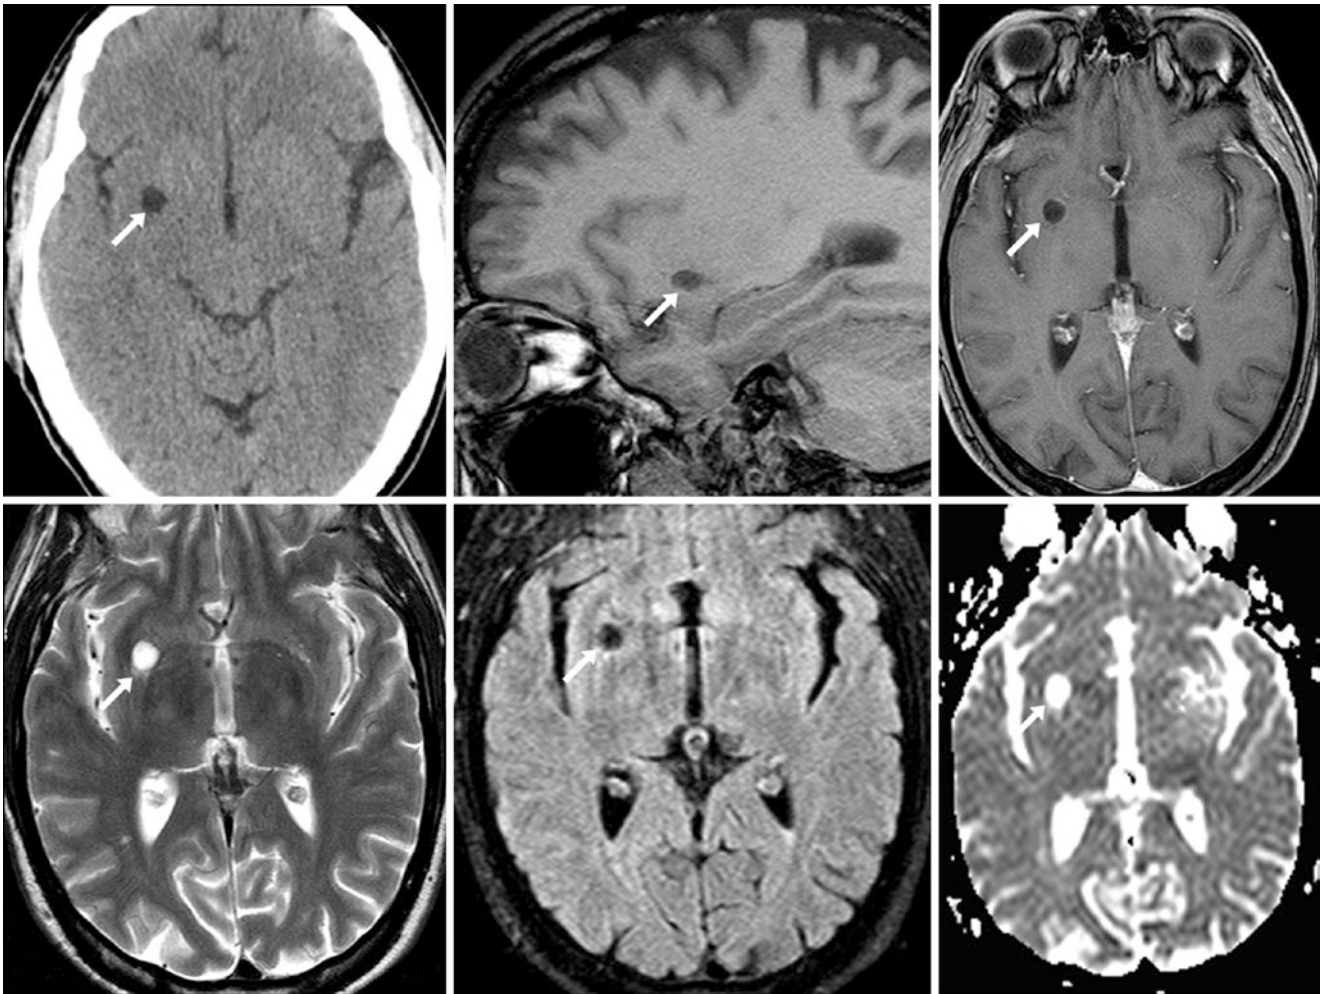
A 52 year old had a dilated PVS (arrows) within the inferior right putamen on a NECT (top left), sagittal T1WI MRI (top middle), postcontrast axial T1WI MRI (top right), axial T2WI (bottom left), FLAIR (bottom middle), and an ADC map (bottom right). As expected, the PVS suppresses with CSF on FLAIR and is bright on the ADC map
